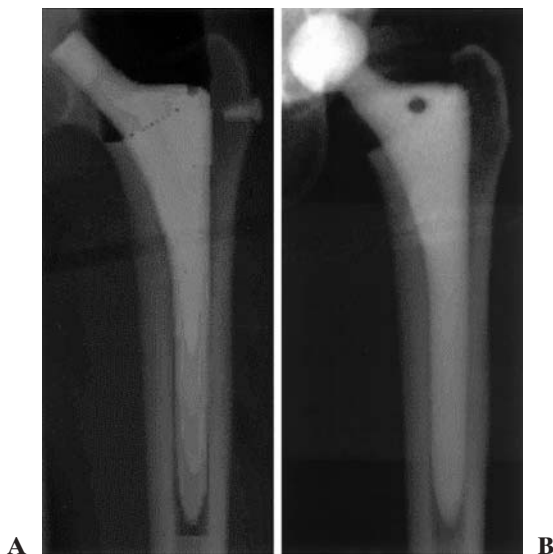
A Anteroposterior synthetic radiograph of the proximal femur of a 53-year-old woman from preoperative planning. B Anteroposterior synthetic radiograph reconstructed from CT data obtained 1 month postoperatively
